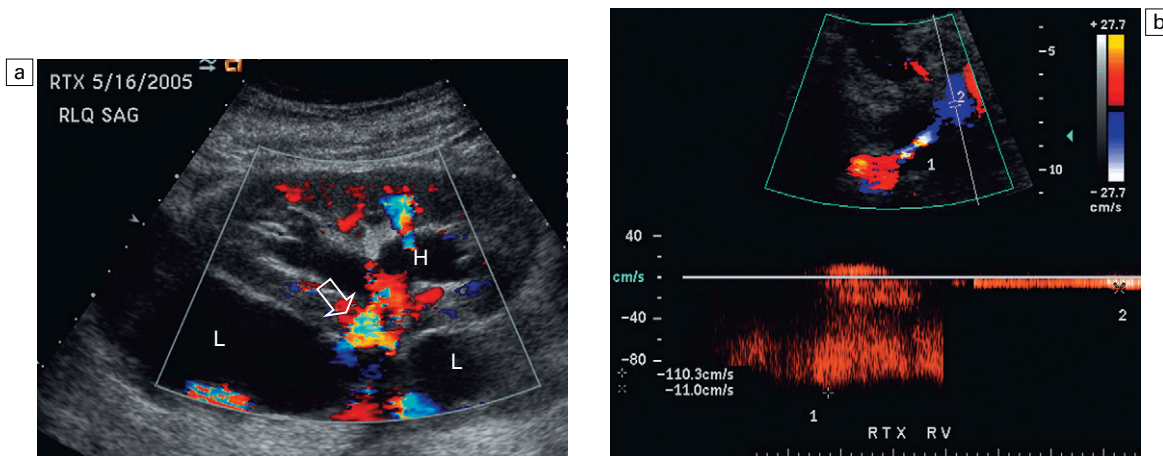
(a) Longitudinal colour Doppler image of this renal transplant shows a large fluid collection medial to the kidney, surrounding the renal vascular pedicle. This is a lymphocele (L) and it has caused distortion of the pedicle. Colour aliasing can be seen in the renal artery (arrow). There is also obvious hydronephrosis (H) caused by compression of the ureter. (b) Spectral Doppler tracing of the renal vein shows marked compression where it courses past the lymphocele (#1), the measured velocity at this area is 1.1 m s^{-1} ; whereas within the kidney (proximal to the lymphocele (#2)) the velocity is only 0.1 m s^{-1} . This 10-fold velocity gradient indicates that this is truly significant renal venous outflow obstruction.
